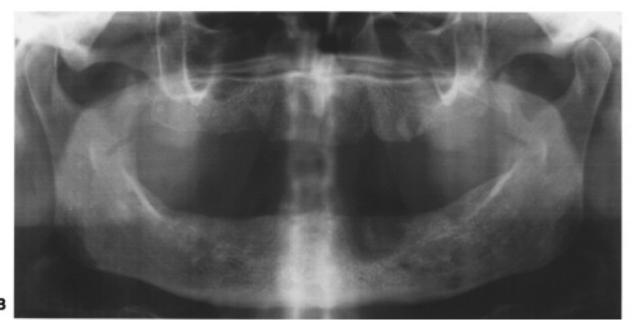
A. Clinical view of multiple fistulae of the mandibular alveolar bone. B. Panoramic radiograph showing an ill-defined radiolucent lesion, which is better demonstrated on CT scan. (C) 3-dimensional reconstruction.
